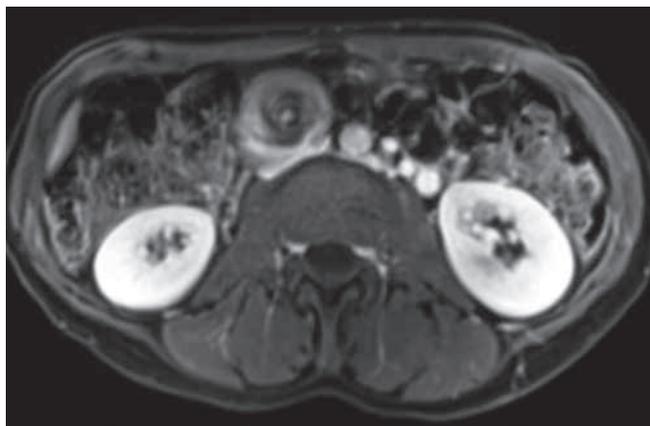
Abdominal MRI: axial T1-weighted slices after contrast injection showing the whirlpool sign enables the imaging diagnosis of midgut volvulus. Clockwise rotation of the small bowel (duodenum and jejunum) around the axis of the superior mesentery artery and vein.
